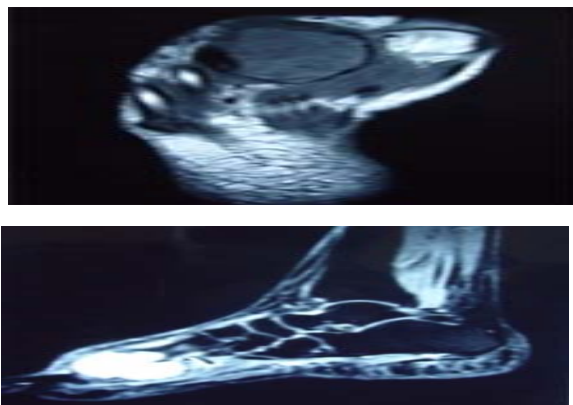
Transverse T1-weighted MR image Fig 4: Sagittal T2-weighted MR image Her MRI showed a low signal intensity lesion on T1 and intermediate signal lesion on T2 images. The signal intensity was homogenous and expanding the second metatarsal. There was no fluid level, no cortical destruction and there was no extra-osseous extent.
